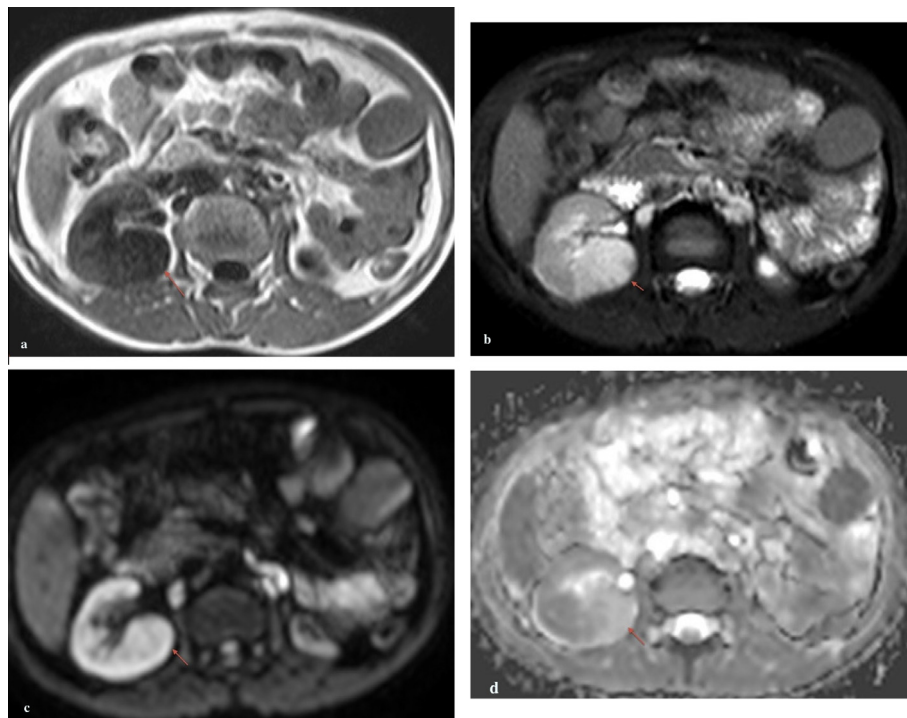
A 17-year old female patient with pseudo-tumour in CKD. Gd-DTPA was not administered owing to impaired kidney function as a result of Systemic Lupus Erythematosus (SLE). (a) Axial T1WI shows a nodular lesion at the medial aspect of the right kidney mildly hypointense to surrounding parenchyma. The lesion is hyperintense on axial fat suppression T2WI (b). Note small atrophic left kidney. (c and d) DWI at b value of 800 and ADC map demonstrate absence of diffusion restriction (ADC value is $2.61 \times 10^{-3} \text{ mm}^2/\text{sec}$). There are wedge areas of diffusion restriction in the surrounding renal parenchyma.
